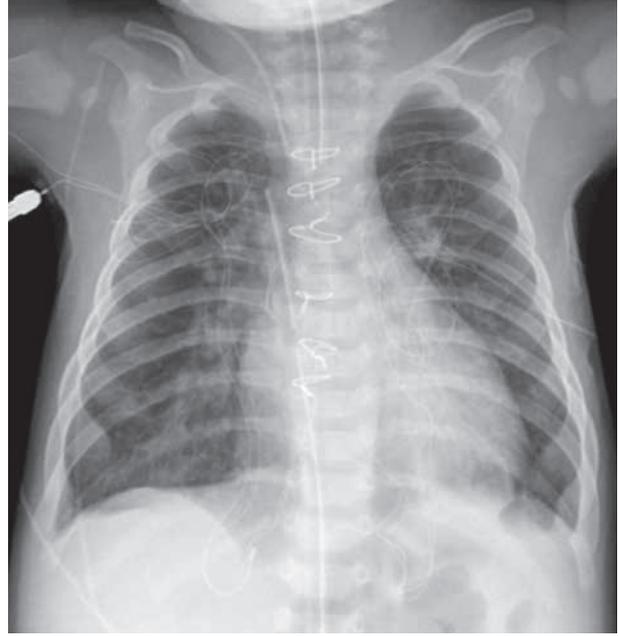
Immediate postoperative thoracic x-ray without additional complications.
